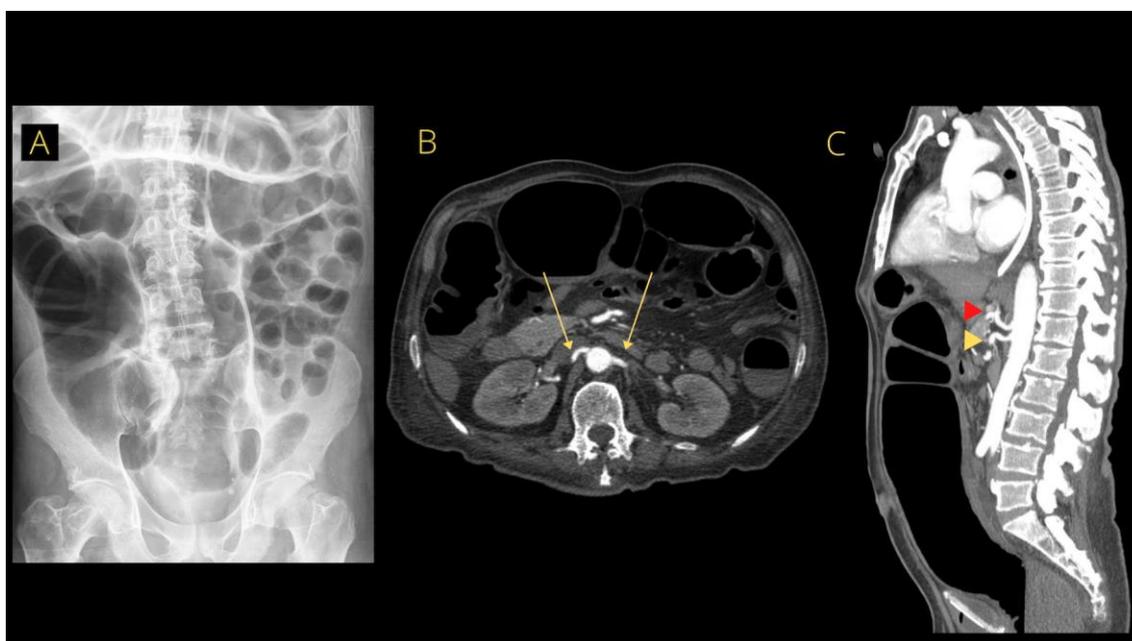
Abdominal X-Ray showing marked diffuse colonic dilation (1A). The contrast abdominal computed tomography shows marked colonic dilation without evidence of mechanical obstruction (1B and 1C). There were no signs of proximal renal artery stenosis (red arrows) (1B). There was also no signs of mesenteric ischemia (1C). The superior mesenteric artery is represented by a red arrow and the celiac artery is represented by the yellow artery.
